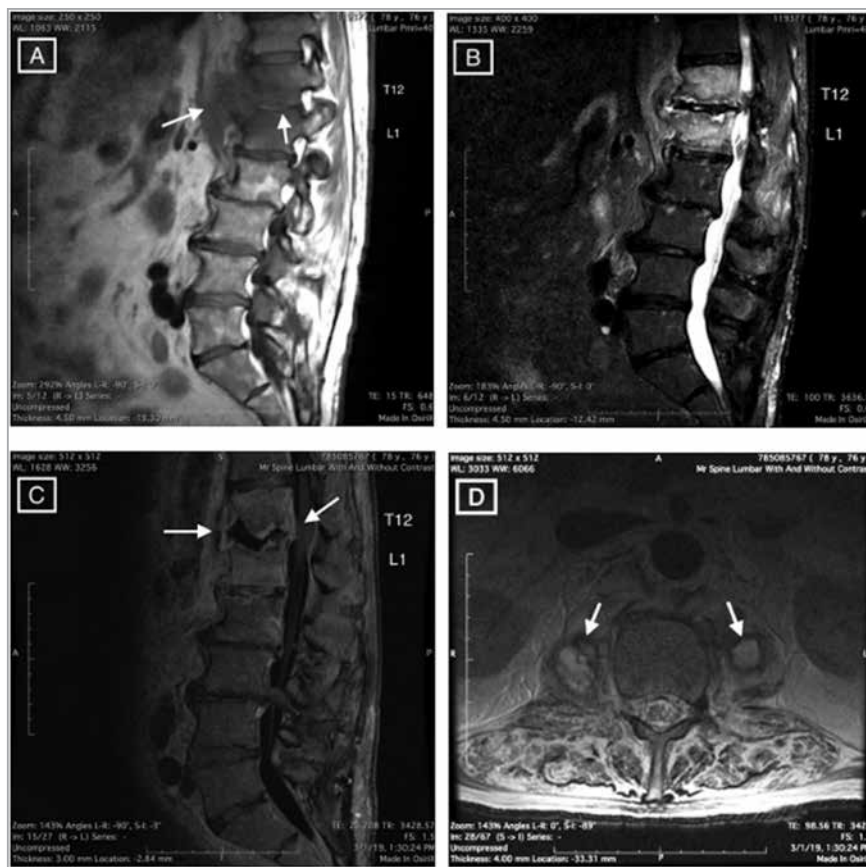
Magnetic resonance imaging showing perpetuation of spondylodiscitis. Top images (A and B) are the initial outpatient images ordered 2 months prior to bottom images (C and D) obtained during the third hospital admission. (A) T1-weighted sagittal view: edema in soft tissue anterior to T12-L1 (left arrow) and edema in vertebral bodies; loss of intranuclear cleft (right arrow). (B) STIR sagittal view: high signal in disc; bright T12 and L1 vertebral bodies indicating edema; fluid accumulation visible in endplates. (C) T1-weighted sagittal view: endplates demineralized; enhancement of T12 and L1 vertebral bodies; disc completely filled with purulent fluid (left arrow); small epidural abscess (right arrow). (D) T2-weighted axial view: bilateral psoas abscesses (arrows); extensive paraspinous phlegmon.
